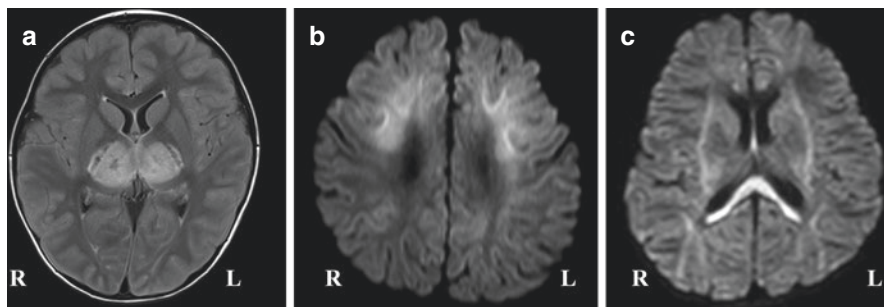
MR imaging findings in influenza encephalopathy. (a) Local high intensity in bilateral thalamus (ANE, T2/FLAIR), (b) bright tree appearance in bilateral frontal and occipital subcortical white matter (AESD, DWI), (c) high intensity area in the corpus callosum (MERS, DWI), *MR* magnetic resonance, *FLAIR* fluid-attenuated inversion recovery, *ANE* acute necrotizing encephalopathy, *DWI* diffusion weighted image, *AESD* acute encephalopathy with biphasic seizures and late reduced diffusion, *MERS* clinically mild encephalitis/encephalopathy with a reversible splenial lesion
